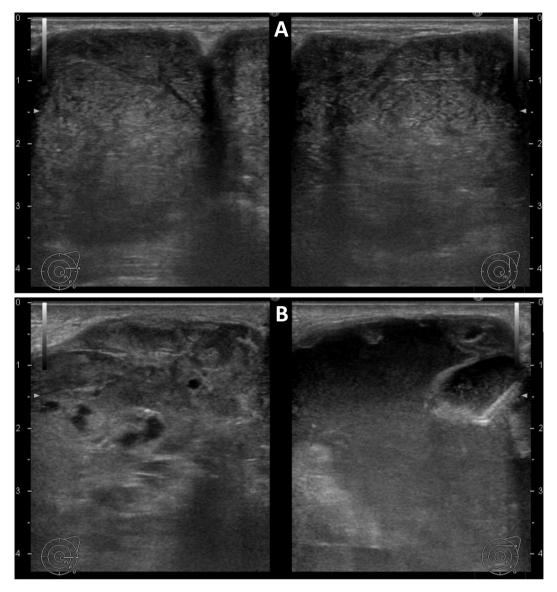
Ultrasonography of the left breast at first presentation (A) and after 3 months of anti-HER2 chemotherapy (B). A well-defined, low-echoic mass with a homogeneous intratumoral echoic pattern could be seen at first presentation (A). After 3 months of anti-HER2 chemotherapy, the mass suddenly enlarged and contained fluid, potentially suggesting intratumoral hemorrhage (B).
